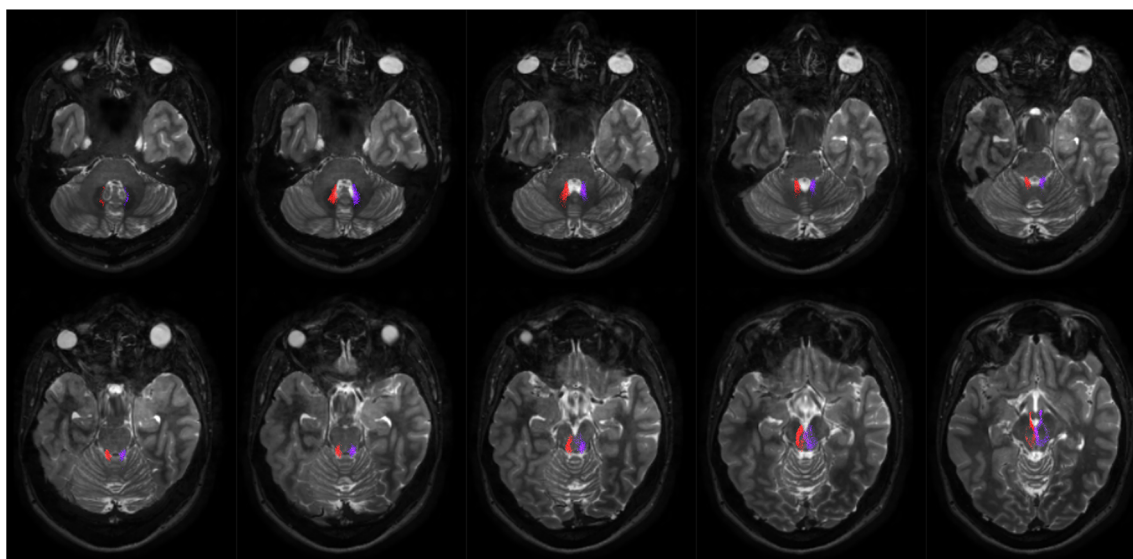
Course of ipsilateral dentate nucleus-mammillary connections. Ten axial T2-weighted images show the course of the connections between the dentate nucleus and mammillary bodies. On the *right side*, fibers are *red* colored and, on the *left side*, *blue* colored. The *first three*
